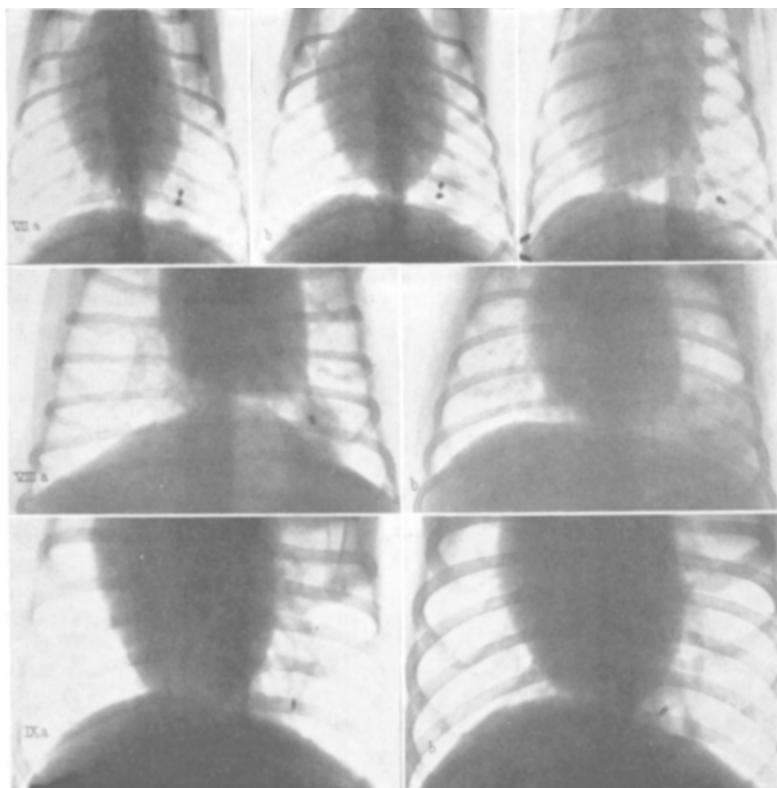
Roentgenograms of Y 10 following introduction of infected embolus into jugular vein.
